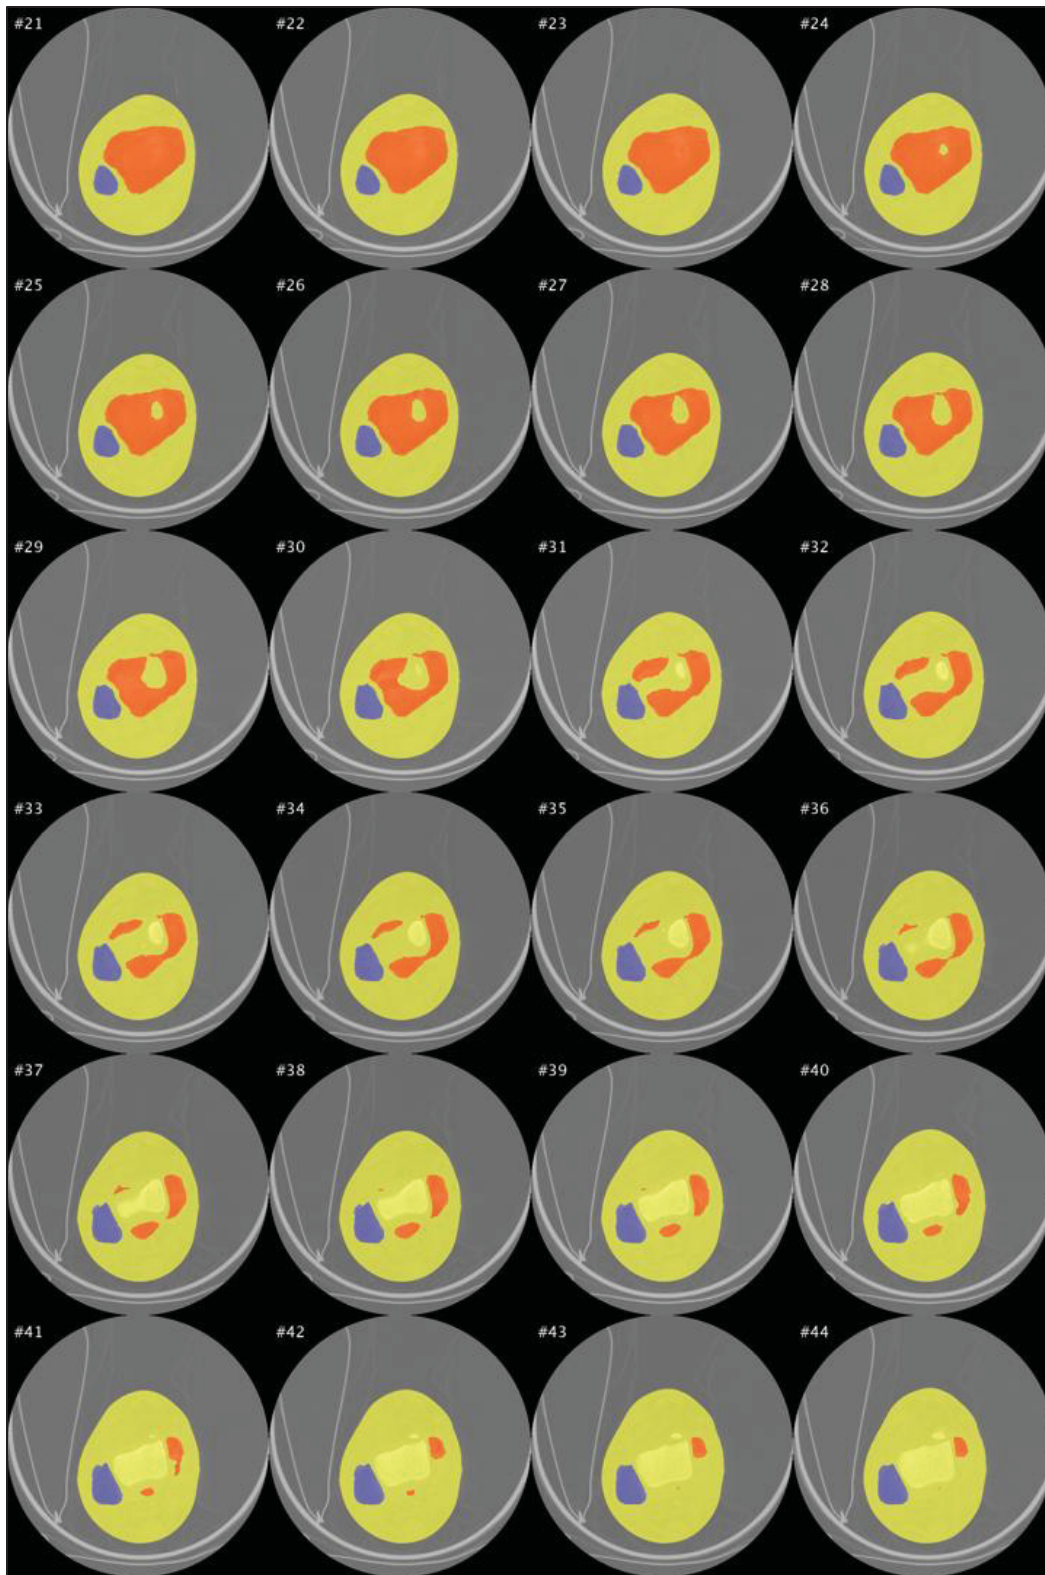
Figure-A I-1: Slice-by-slice segmentation for a CT-Scan sample, slice 1 to 44
